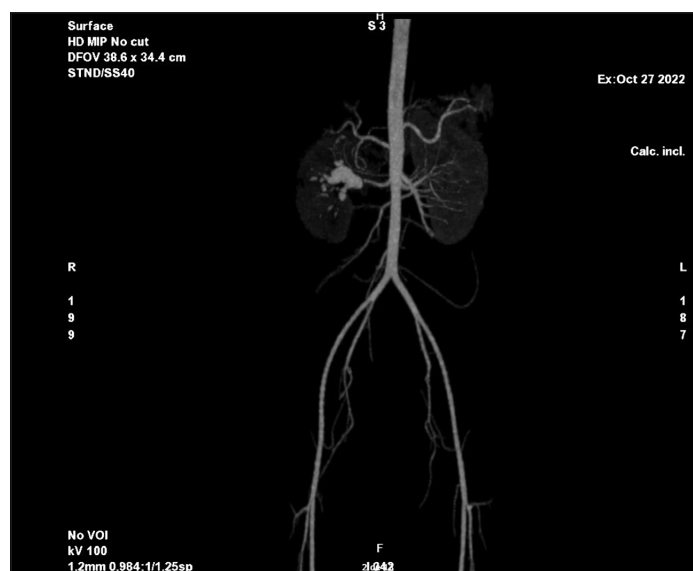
Abdominal angio-CT with contrast. Fusiform aneurysm of the right renal artery.
